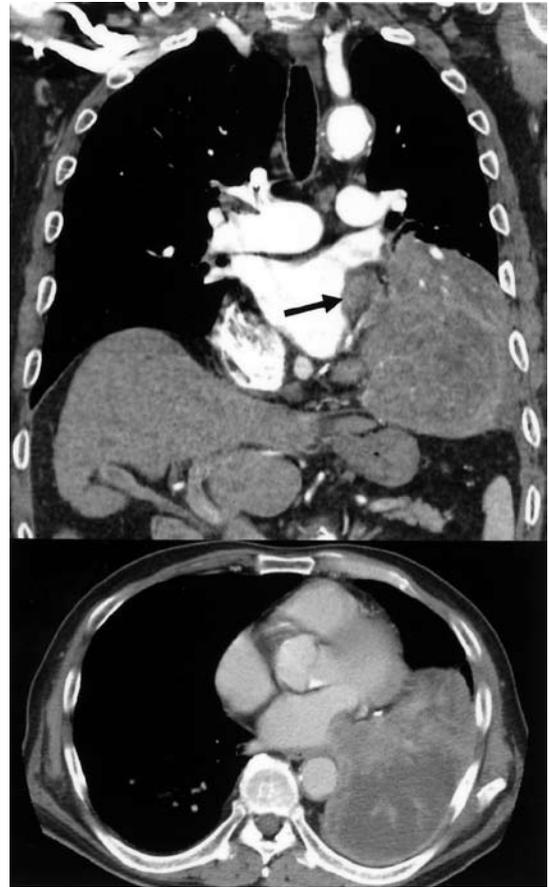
Chest CT scans disclose a giant tumor almost completely occupying the left lower lobe. Blood flow through the left inferior pulmonary vein is not visualized, strongly suggesting tumor invasion of the left atrium.
